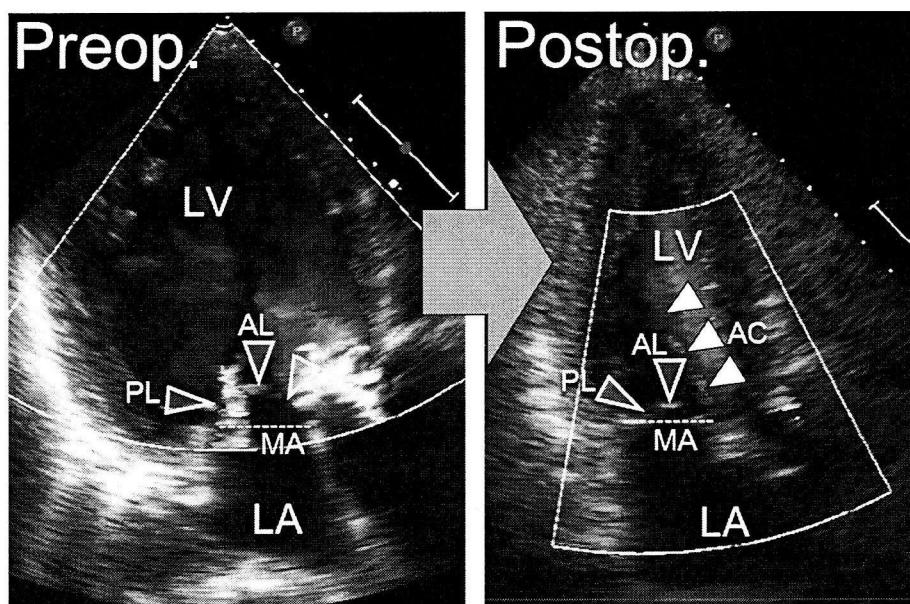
Echocardiography of a representative patient. A 64-year-old woman underwent the Bentall procedures and PHO relocation of the PMs via an aortic orifice. One year after the surgery, leaflets tethering, functional MR, and LV dilatation/sphericalization disappeared. Note that the patient did not receive mitral annuloplasty or left atriotomy. White triangular markers show artificial chordae for relocation. LV, Left ventricle; AL, anterior leaflet; PL, posterior leaflet; MA, mitral annulus; LA, left atrium; AC, artificial chordae.
